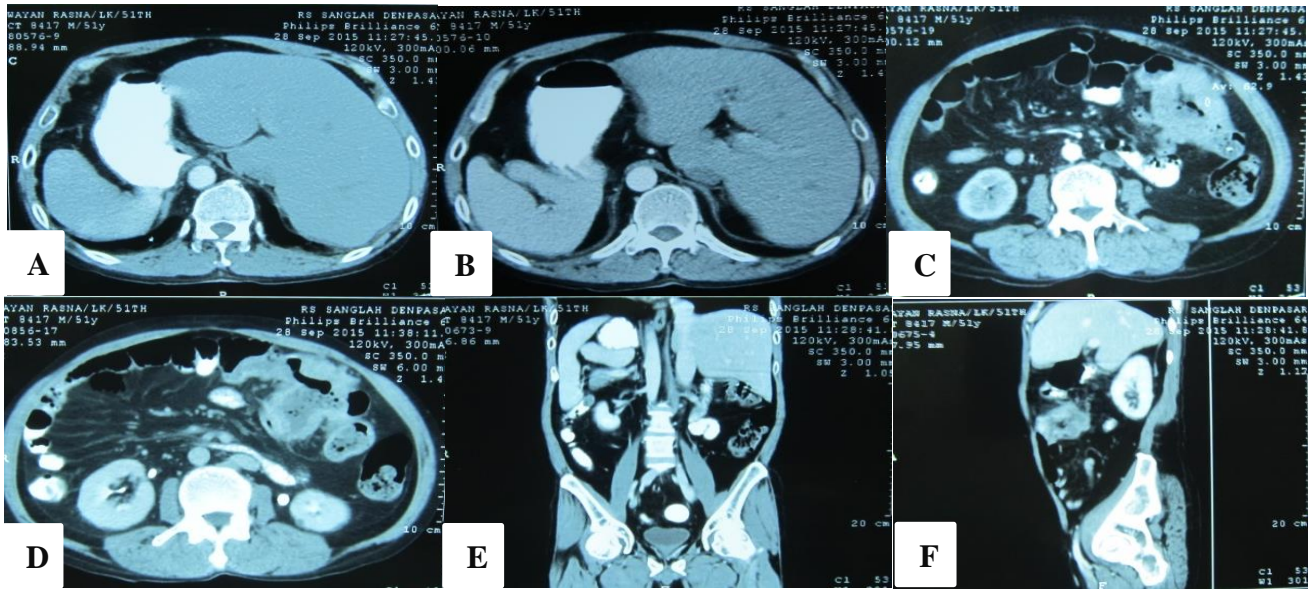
Abdominal CT-Scan with contrast. (A and B) The liver was on the left side, while the spleen was on the right side (axial view). (C and D) The ascending colon was on the left side (axial view). (E) Situs inversus (coronal view). (F) Situs inversus (sagittal view).
